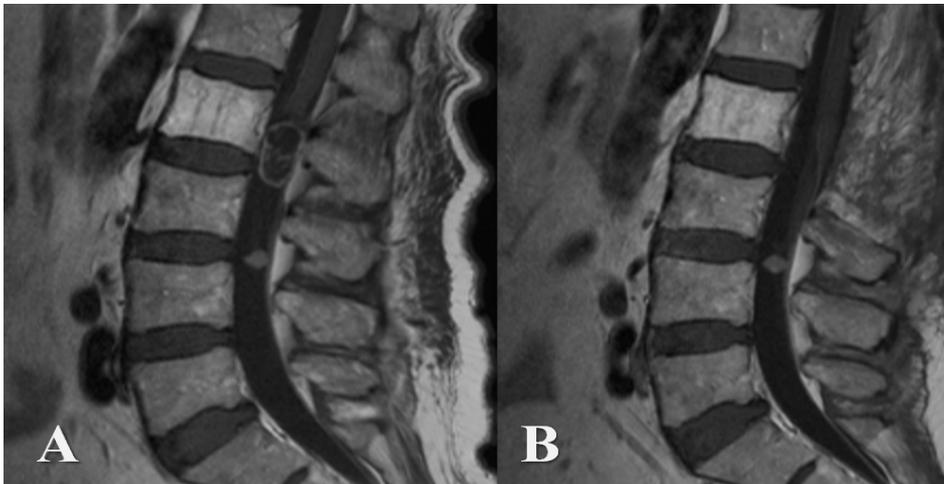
Preoperative (A) and postoperative (B) gadolinium-enhanced MRI images (2011)
